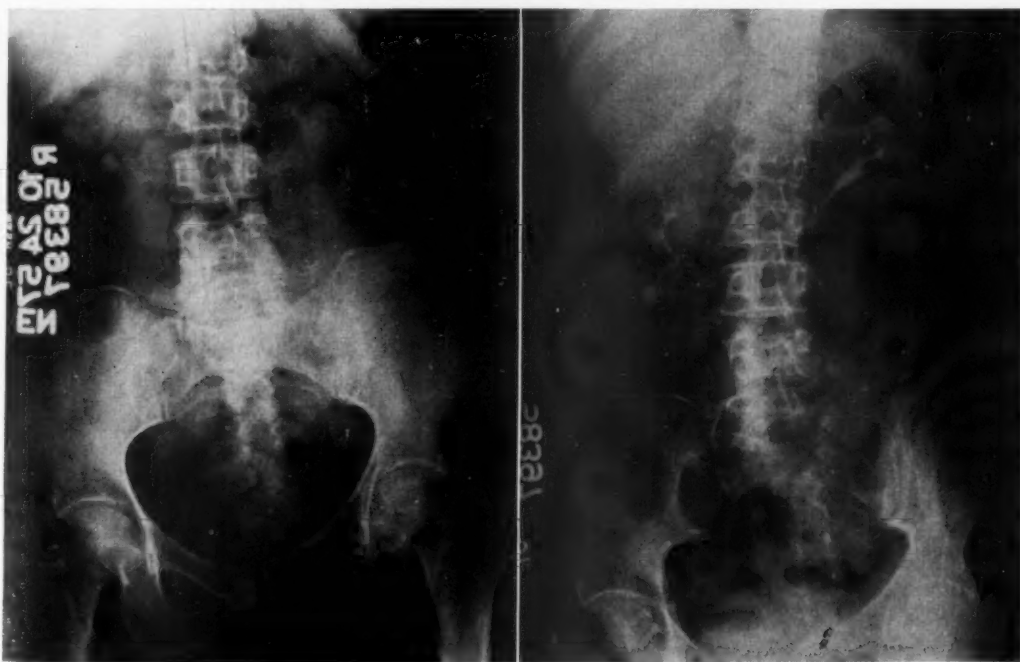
X-rays of the pelvis showing mass in the area of the fifth lumbar vertebra, with lysis of this vertebra and its transverse process and a displacement of the left ureter by the pelvic mass.
